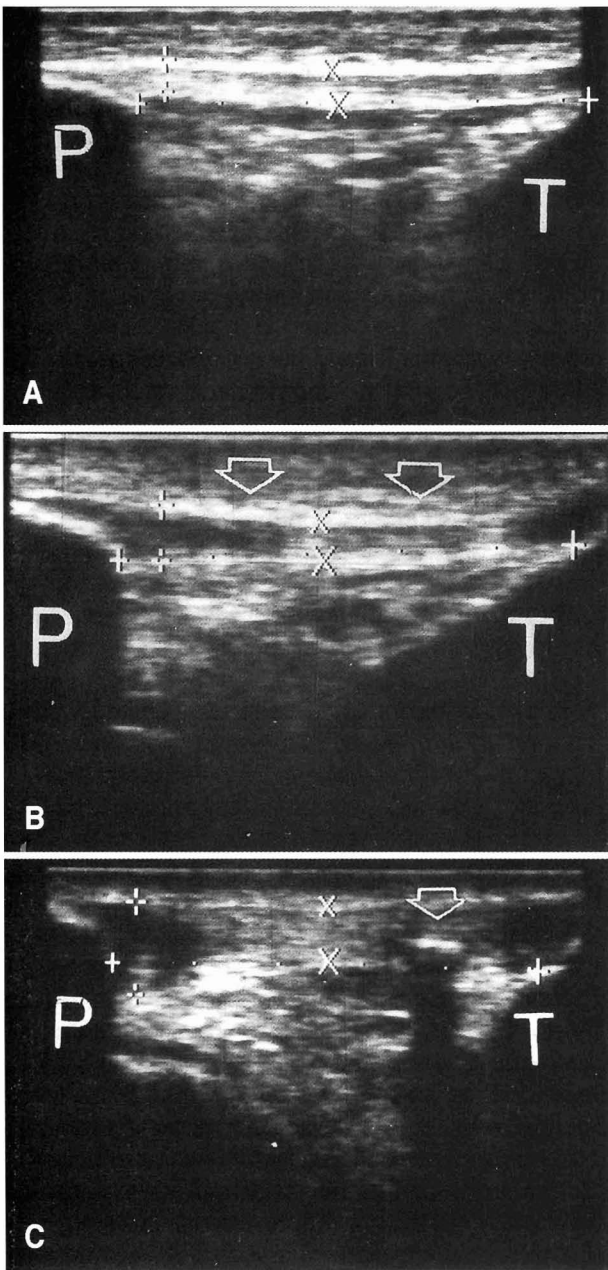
(A) Ultrasonogram of a normal patellar tendon. Note the uniform thickness in the proximal and distal parts of the tendon and the homogeneous echogenicity. P denotes the distal tip of the patella, and T denotes the tibial tuberosity. The crosses denote the reference points used for the length and thickness measurements (Fig. 2). (B) The patellar tendon of a player with no previous or present history of jumper's knee. The ultrasonogram shows thickening (arrows) of the proximal part of the tendon, which also is hypoechoic. There is also thickening of the paratenon in the central part of the tendon. (C) The patellar tendon of a player with grade III symptoms (modified Blazina-Roels classification). Note thickening of the entire tendon with marked hypoechoic changes in the proximal part. Also note the hyperechoic zone (arrow) in the distal part of the tendon (calcification after partial tear?).
